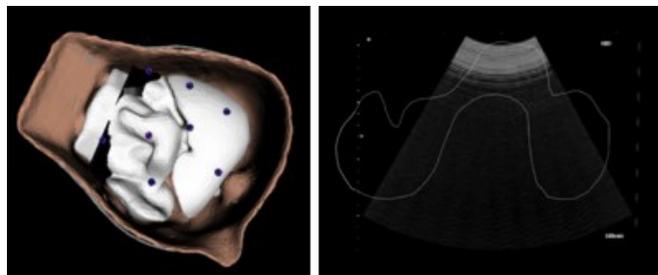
CT scan model with USG image (left). USG image with a section from CT model
